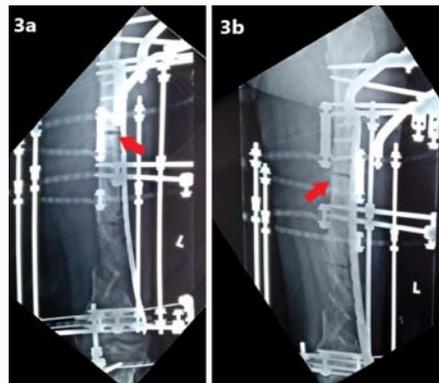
The immediate postoperative radiographs showing the Anteroposterior (AP) (3a) and oblique (3b) views of the left femur. The red arrows denote the area of corticotomy done, which is just proximal to the location of previous 2 locking screws which were removed. The presence of the plate and the circular frame construct provide necessary mechanical stability in this fracture pattern, and the plate acts to guide the transport segment towards the docking site at the distal femur.
